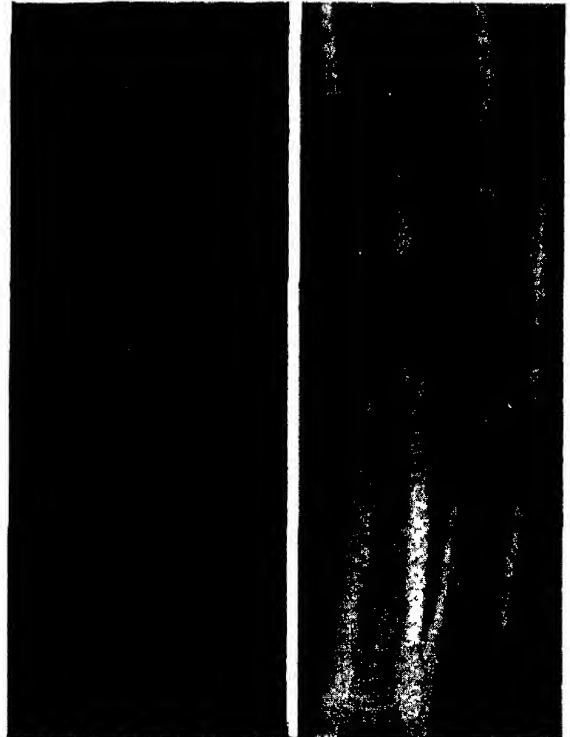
A, Neurilemmoma midshaft of right ulna, Case 1, July 18, 1932. B, Roentgenogram taken May 21, 1935. (DeSanto and Burgess: Surg., Gynec. and Obst.)
